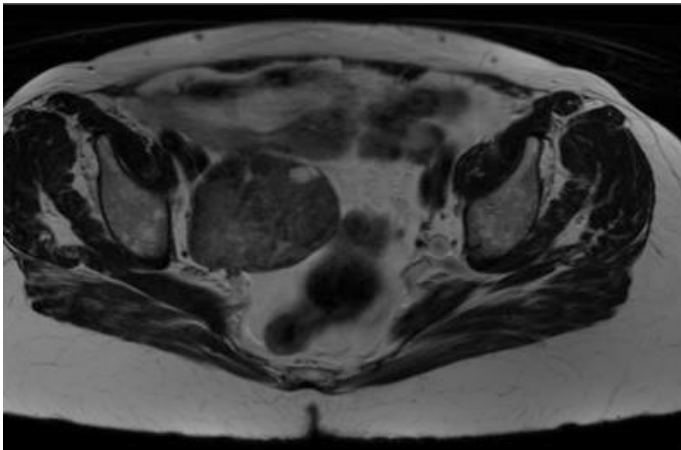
MRI shows a solid mass in the right adnexa.
